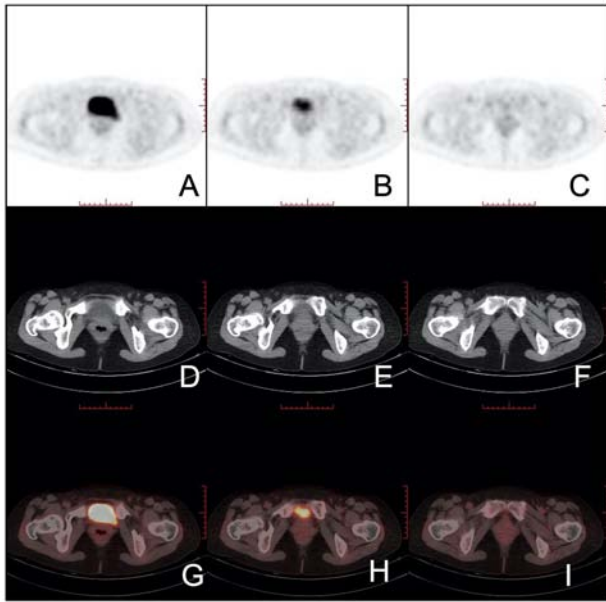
Typical PET/CT scan images of a patient with no postoperative tumor recurrence and metastases for cervical cancer. (A-C) PET images. (D-F) CT images. (G-I) Fusion images of PET and CT images. The patient was 51 years old. After cervical CC surgery, there is an absence of the uterus and bilateral appendages, and there is no obvious abnormality in the distribution of imaging agents in the corresponding areas. PET, positron emission tomography; CT, computed tomography.
